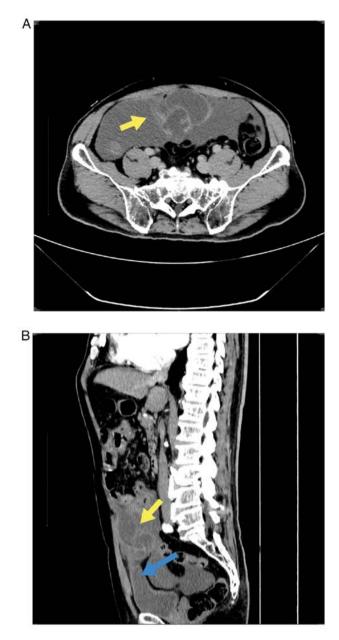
Abdominal contrast-enhanced computed tomography examination. (A) Multilocular cystic mass (yellow arrow) in the urachus area with a significant enhancement of the cyst wall and extensive exudation in the abdominal pelvic cavity. (B) The cystic mass (yellow arrow) is attached to the top of the bladder (blue arrow).
